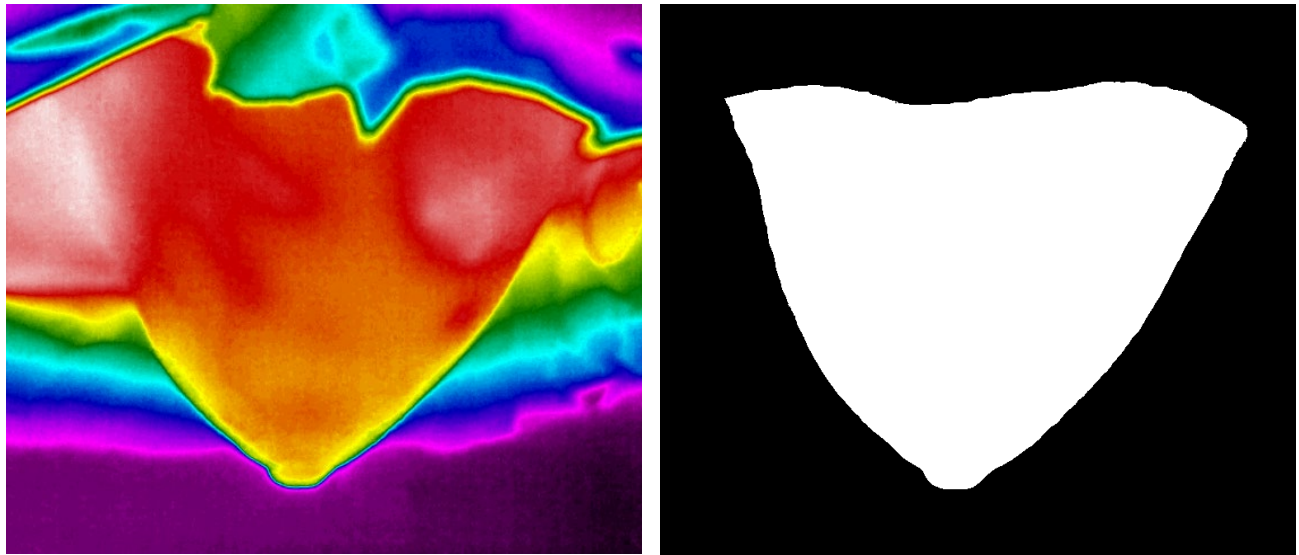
Edge of the IRI image found and silhouette created for patient-specific digital breast model without the need of MRI images.
